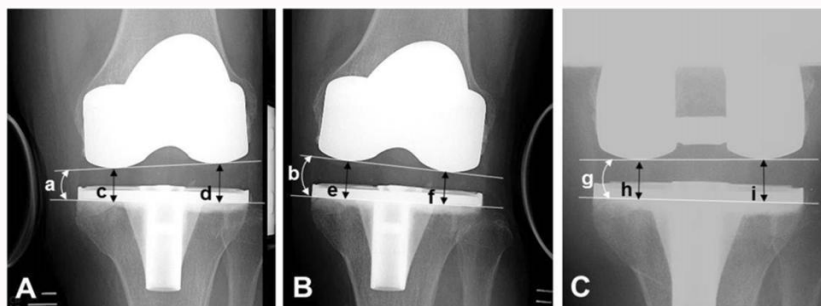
The postoperative assessments of the ligament balance on the varus (A) and valgus (B) stress radiographs at full extension and the stress epicondylar view radiograph at 90° of flexion (C). At extension (A and B), the joint component gap was expressed as $(a+b+c+d)/4$, and the ligament balance in varus as “a - b.” At 90° of flexion (C), the joint component gap was expressed as $(h + i) / 2$, and the ligament balance in varus as “g.”
